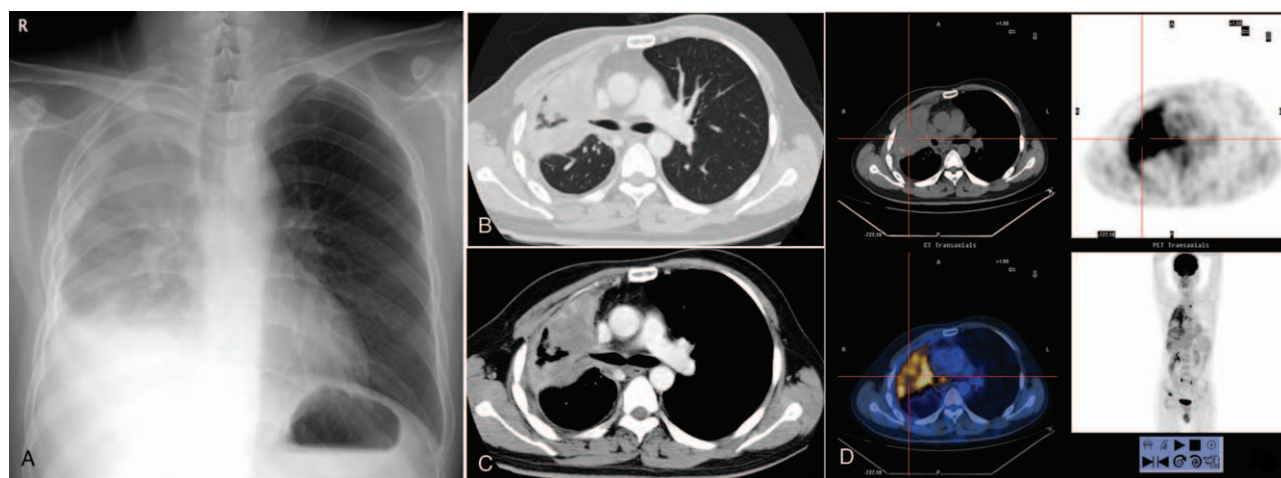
A 30-year-old male presented with a cough, weight loss, and night sweats that had lasted 2 months (subject 5). A, The chest radiograph shows a large patchy opacity in the right lung, mild pleural effusion, and mild volume loss in the right hemithorax. B, CT image shows a large patchy consolidation with inhomogeneous density in the upper lobe of the right lung. C, Contrast-enhanced CT image shows heterogeneous enhancement consolidation in the right upper lobe, with extensive irregular thickening of the right pleura. D, PET/CT scan shows the patchy lesion in the right upper lobe lesion with a significantly high FDG uptake (SUVmax 11.2), diffuse right pleural thickening with SUVmax 5.8 and multiple systemic bone metastases.
